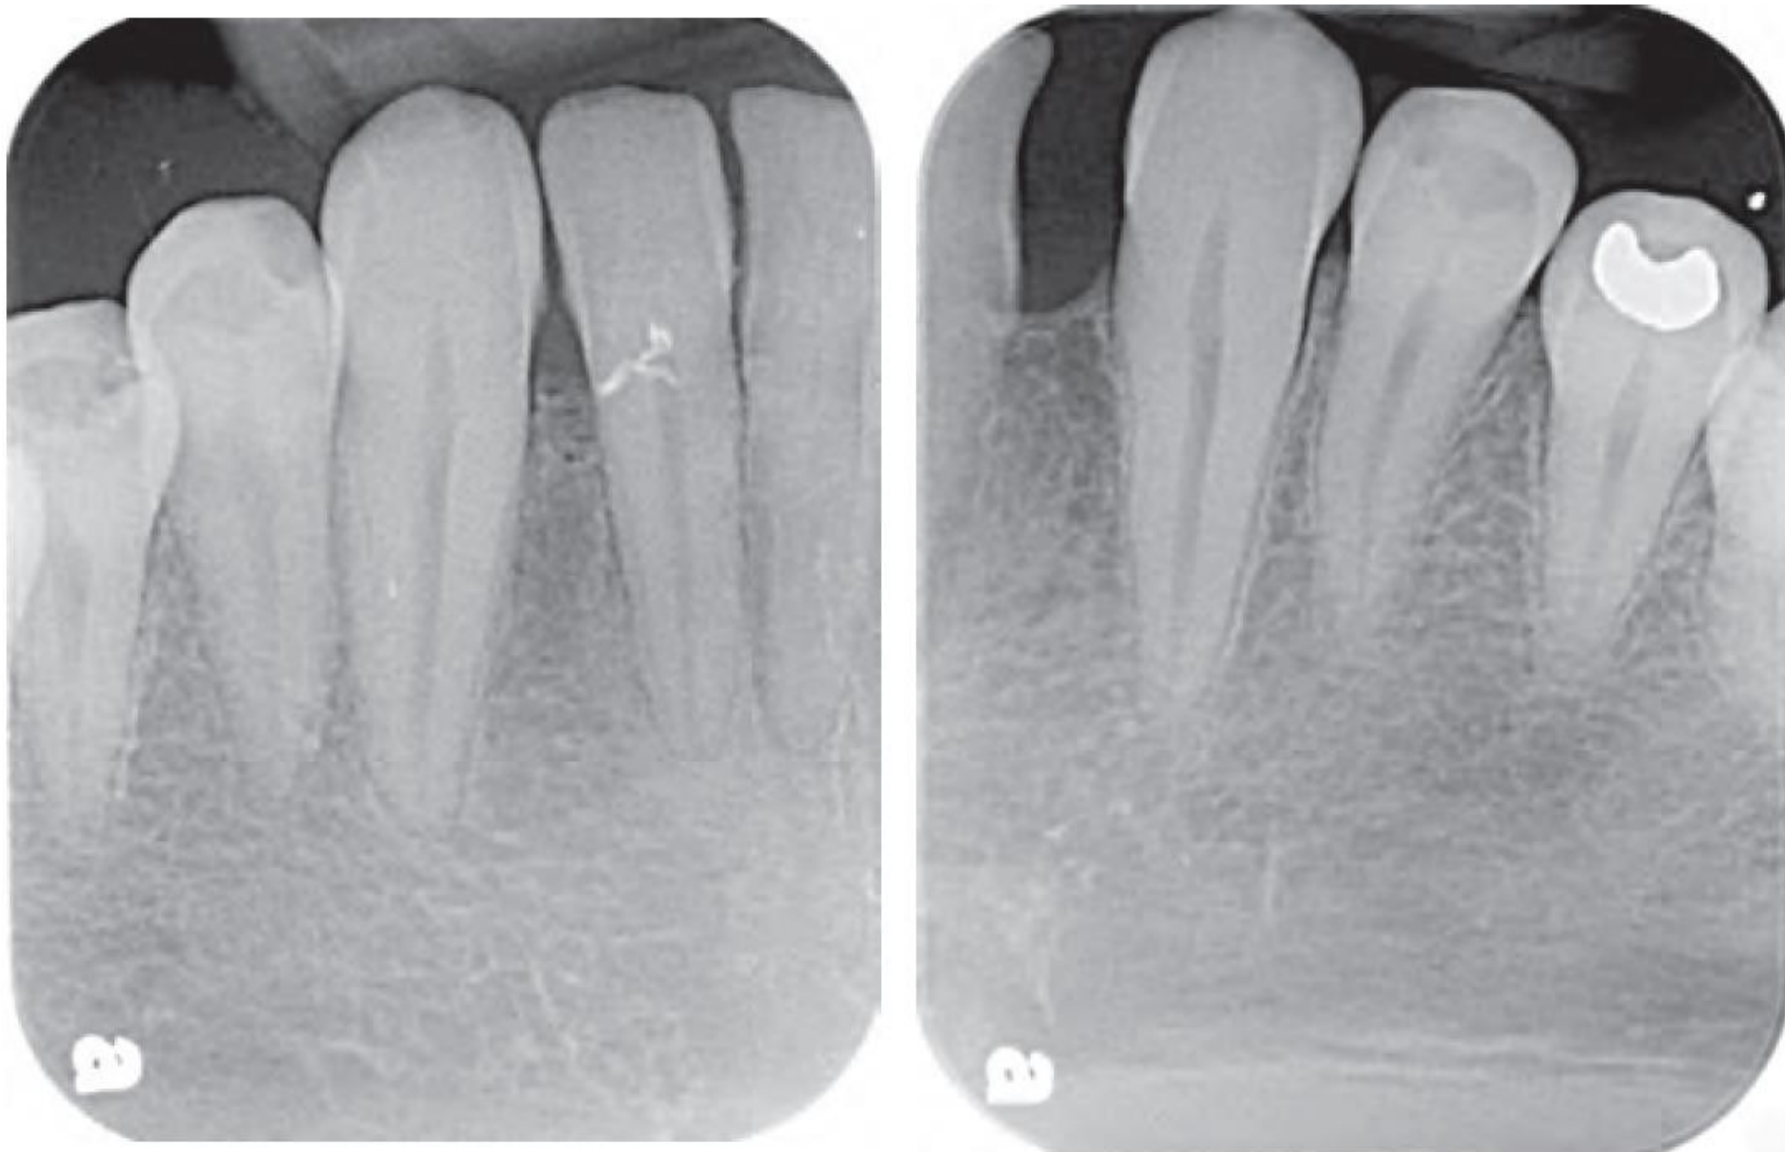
Periapical radiographs showing loss of lamina dura and “ground glass” appearance of renal osteodystrophy in a 36-year-old male with type 1 diabetes and ESRD on HD awaiting a kidney/pancreas transplant.
